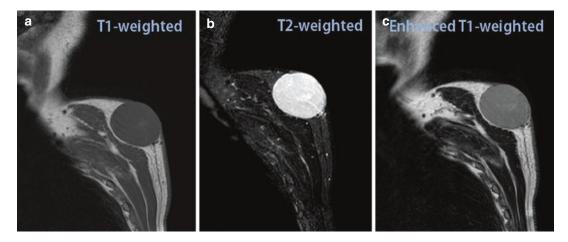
(a–c) Parasagittal T1- (a), T2- (b), and postcontrast T1-weighted MR images of the upper back. Oval tumoral lesion with sharp delineation and limited to the subcutis; no signs of invasion to deeper soft tissue. The tumor was resected with wide margins. Follow-up after 24 months (not shown) revealed no recurrence (Reprinted with permission from Goto et al. [55])
